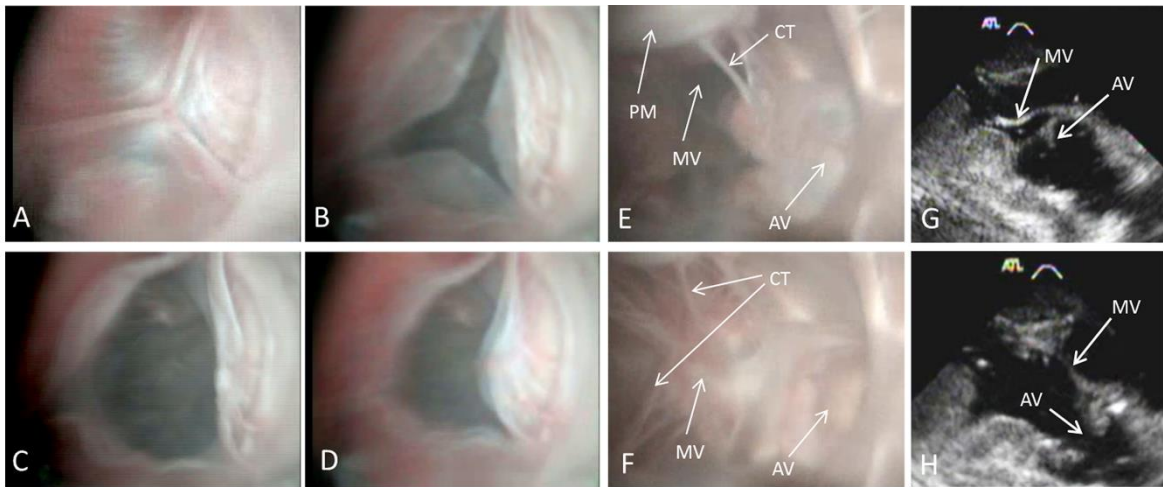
Left: sequence of endoscopic images showing the opening and closure of the aortic valve (A, B, C, D). Centre: endoscopic images (E, F) obtained from the apical access, showing the opening and closure of the mitral and aortic valve (MV, AV). The apical access enable the visualization of both the chordae tendineae (CT) and the papillary muscles (PM). Right: echocardiographic images of the diastole (G) and of the systole (H) showing the mitral and aortic valves (MV, AV).
